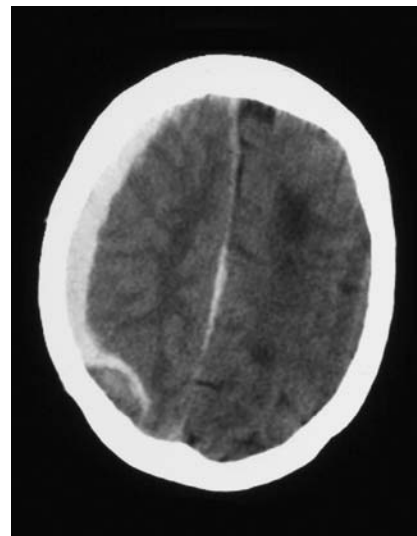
Computed tomography head scan showing large subdural haematoma. The patient had been treated with antiplatelet therapy for symptoms thought to be due to transient cerebral ischaemia. He required a craniectomy and a prolonged period of neurorehabilitation.
